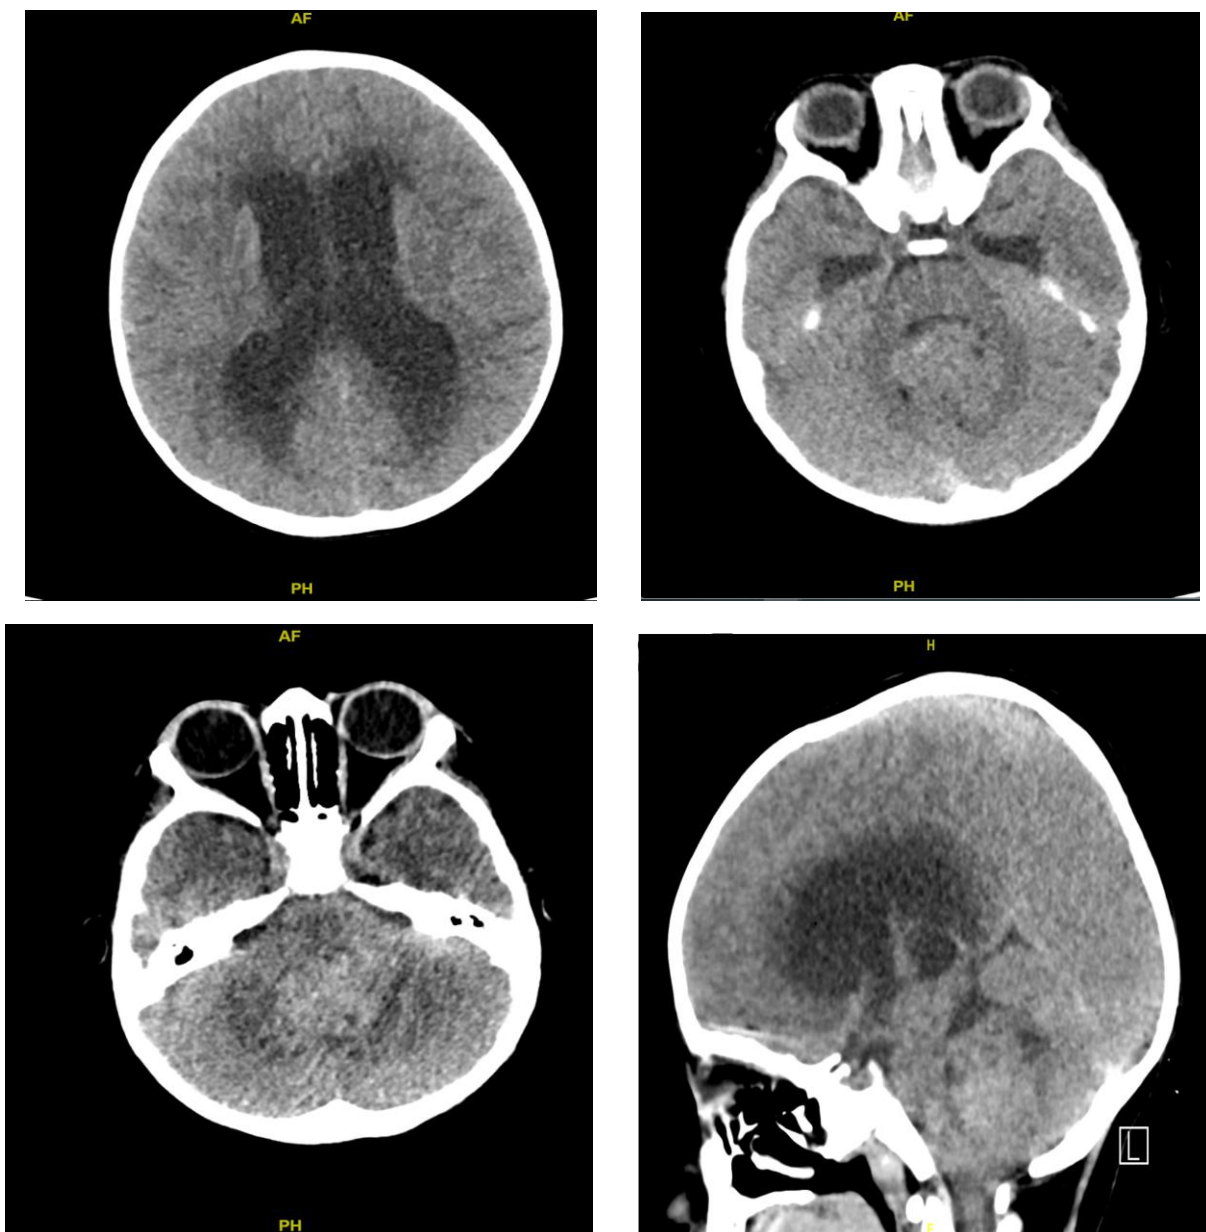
Non-contrast CT axial image of the head indicating a cerebellar mass.
